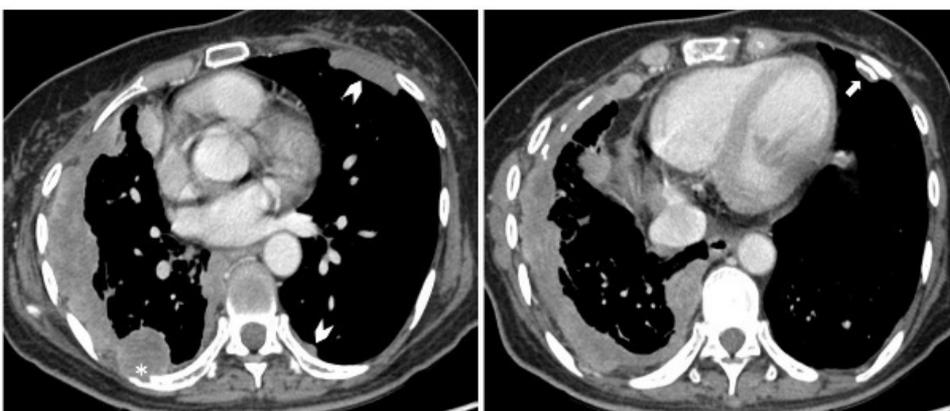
CT scan of a patient diagnosed with MPM. Axial CT scan shows circumferential pleural thickening at right hemithorax with rib destruction (*). A few calcified (arrow) and non-calcified (arrow head) pleural plaques at left hemithorax are also demonstrated.
